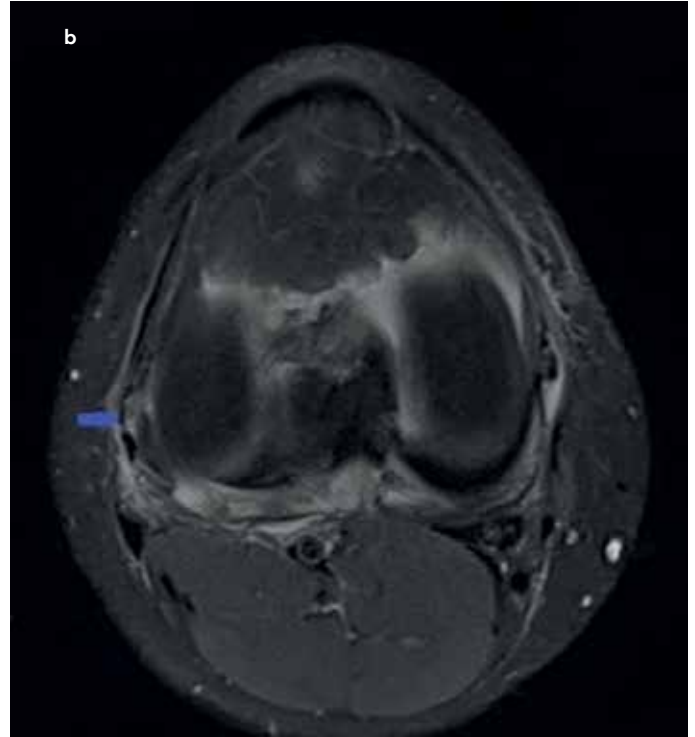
a, b. Coronal proton-density MRI image of the knee: The arrow marks disruption of the femoral part of the anterolateral ligament (a) Axial proton-density MRI image of knee: The arrow marks anterolateral ligament (b).
